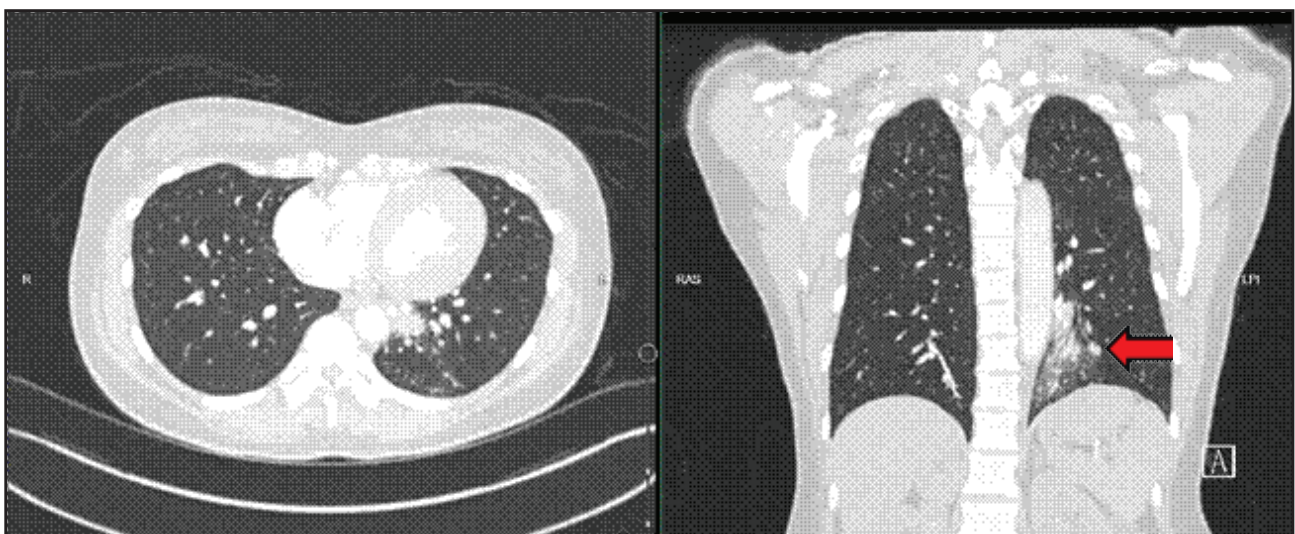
Axial and coronal sections of CT angiography scan demonstrating a masslike consolidation in the posterior basal segment of the left lower lobe (arrow). An anomalous systemic artery arising from the descending thoracic aorta supplies the lesion, consistent with intralobar pulmonary sequestration.
